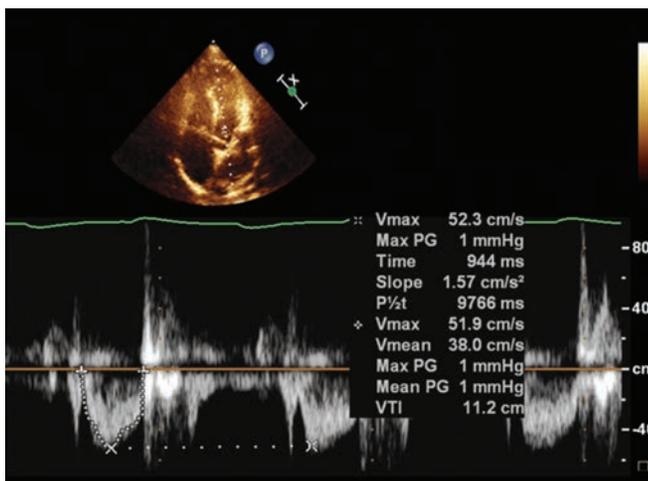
LVOT flow Doppler.
